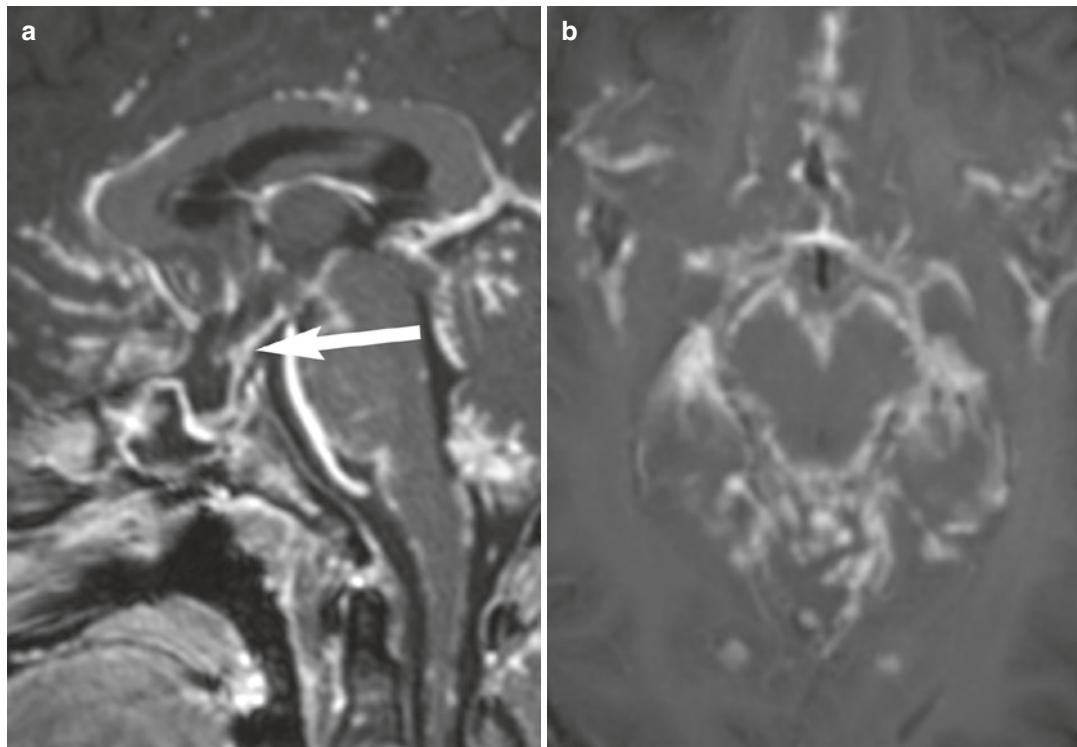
Neurosarcoidosis*. A 35-year-old female with systemic sarcoidosis presented with altered mental status. Sagittal (a) and axial (b) contrast-enhanced T1-weighted
